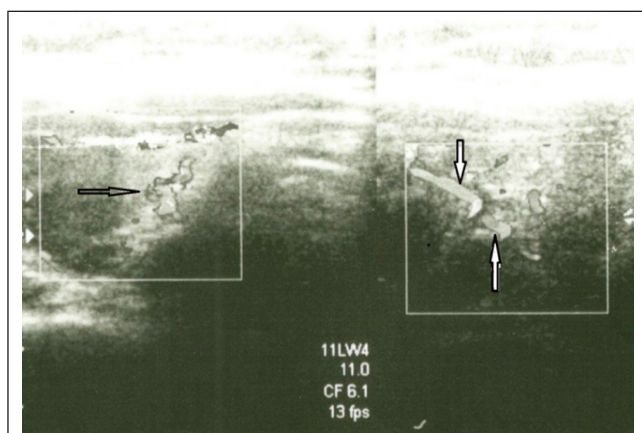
Doppler scan of thyroid gland showing increased vascularity.
